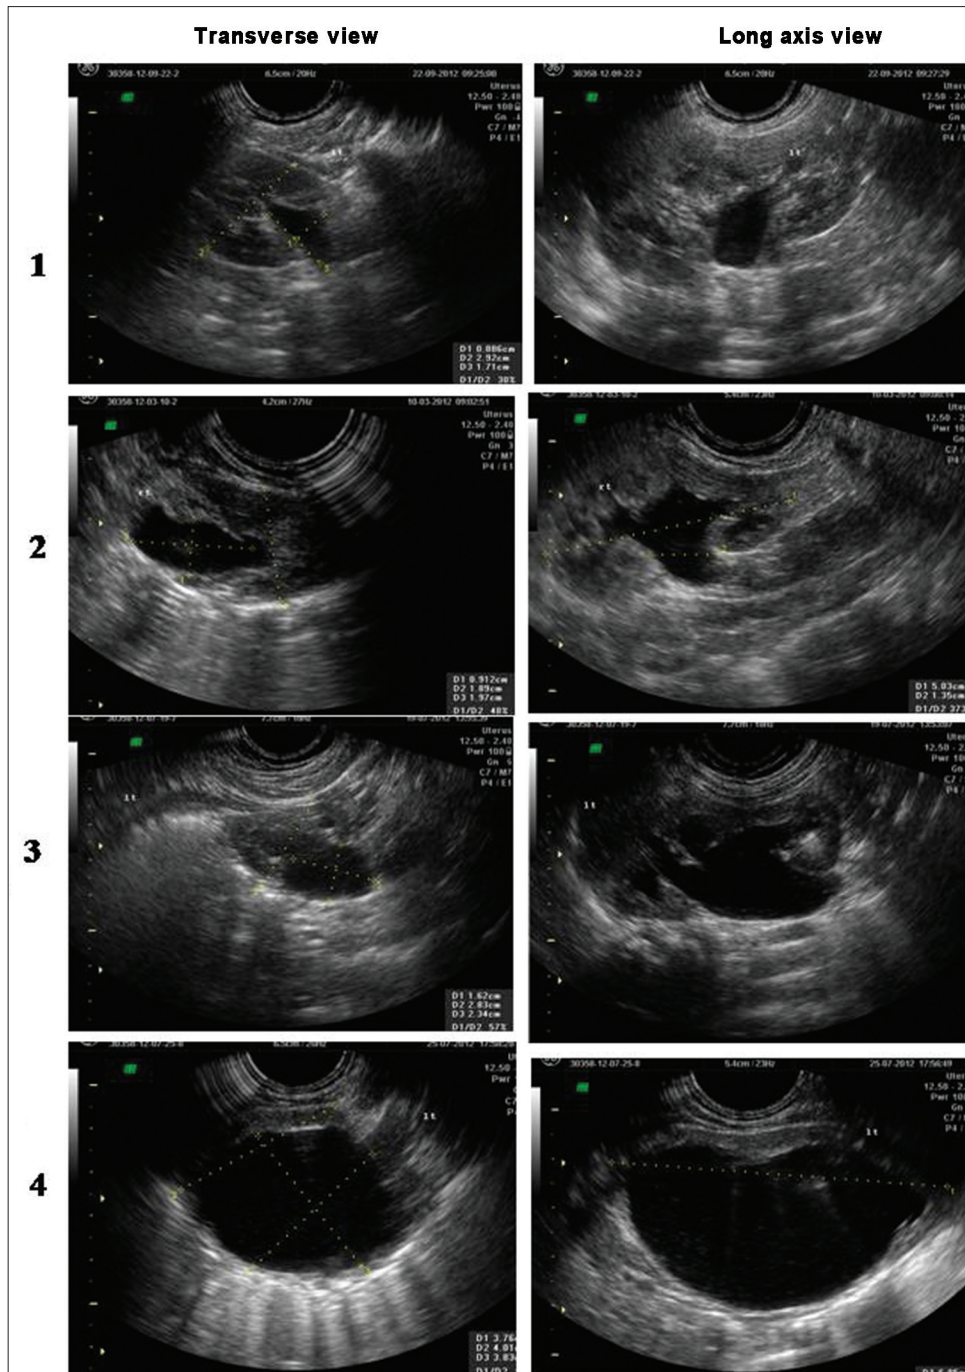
Postnatal ultrasounds depicting the different grades of hydronephrosis according to the Society of Fetal Urology classification. Grade 1: Slight separation of the central renal echo complex. Grade 2: Renal pelvis is further dilated and a single or a few calyces may be visualized. Grade 3: Renal pelvis is dilated and there are fluid filled calyces throughout the kidney, but renal parenchyma is of normal thickness. Grade 4: As grade 3, but renal parenchyma over the calyces is thinned
